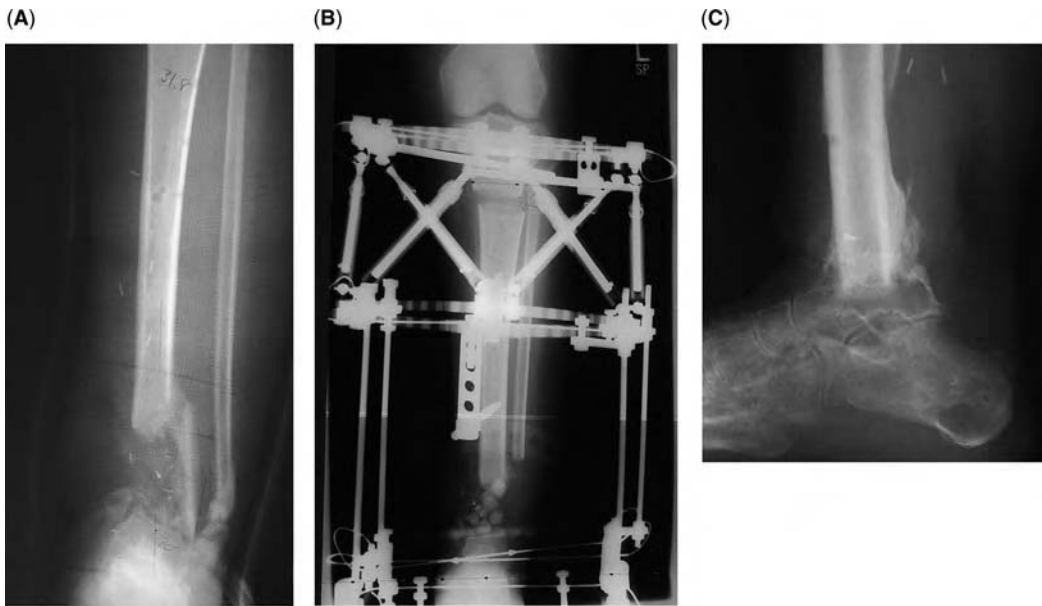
(A) Anteroposterior (AP) radiograph showing an infected nonunion bone defect of the distal tibia and articular surface. (B) AP radiograph showing a two-level frame for proximal tibia lengthening and gradual shortening of the defect and ankle fusion. (C) Lateral X-ray showing a successful ankle fusion. A 10 cm proximal tibia lengthening was performed in this patient.
